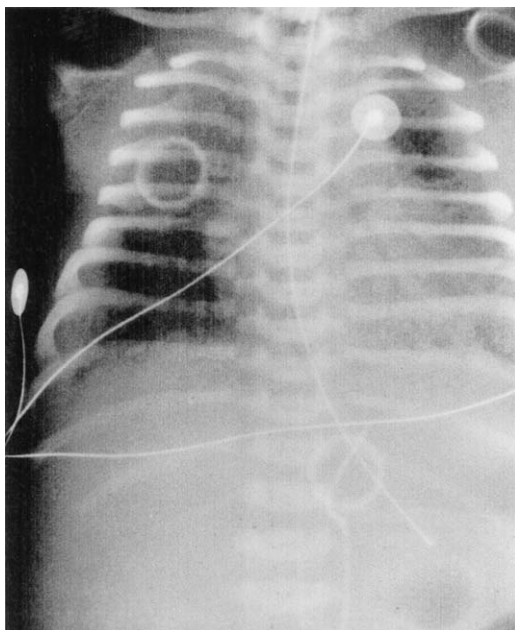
Chest radiograph of a full-term infant with MAS.
